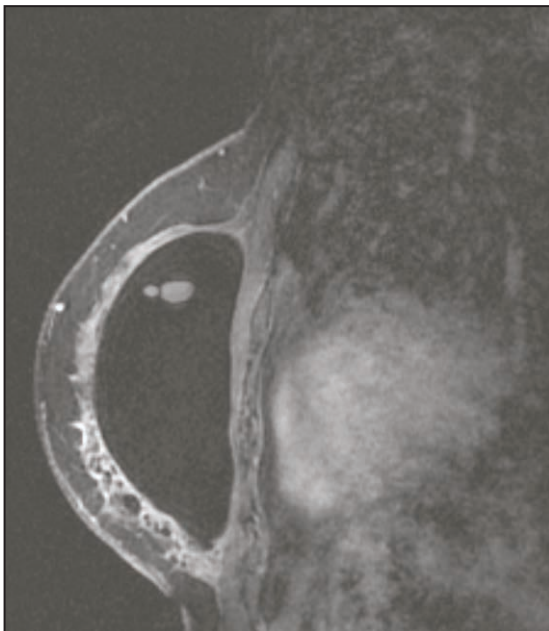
MRI mammography showing bubble in implant
